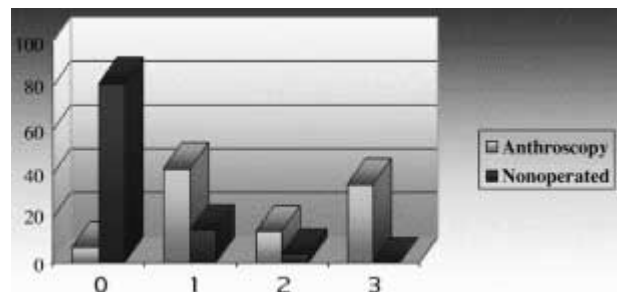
Radiographic results
